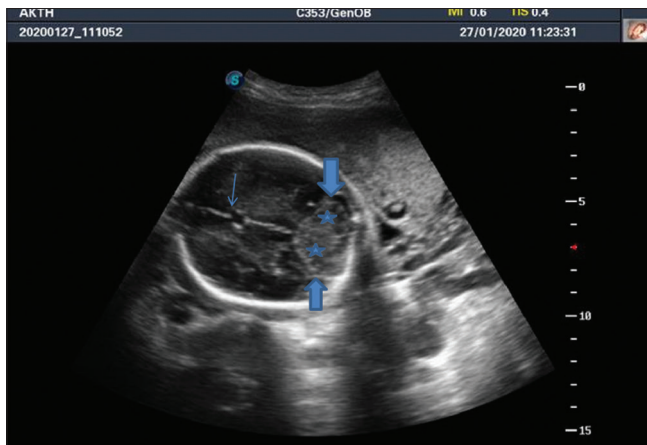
Sonographic axial image of the fetal head depicting plane for measurement of transverse cerebellar diameter. The thalami, cavum septum pellucidum (thin blue arrow), and third ventricle were identified, with the posterior fossa showing the characteristic butterfly-like appearance of the cerebellum (*). The TCD is measured from the outer margins of the cerebellum (as shown by thick blue arrows)
